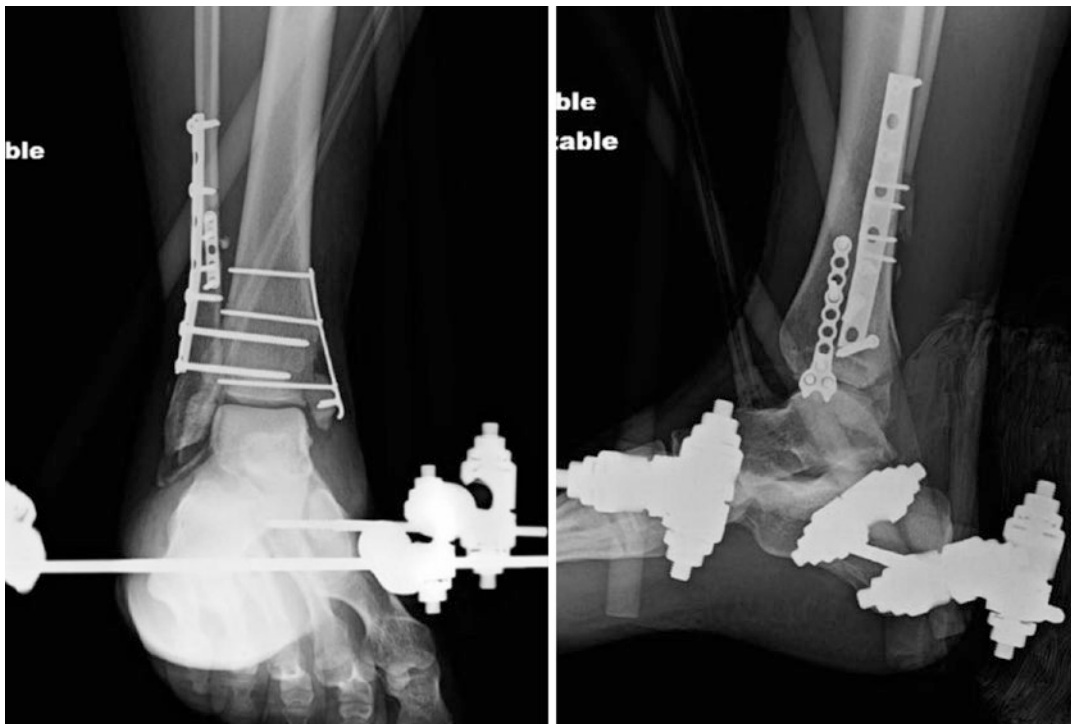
Immediate postoperative radiographs demonstrating definitive fixation of the bimalleolar ankle fracture, syndesmosis, and adjustment of the external fixator
